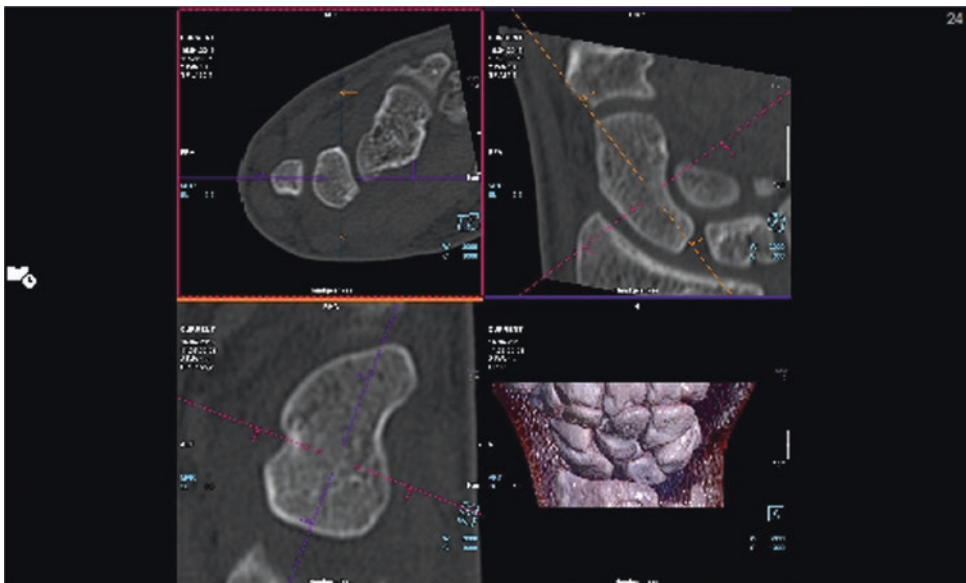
Inconspicuous computed tomography: multiplanar reconstruction (MPR)
